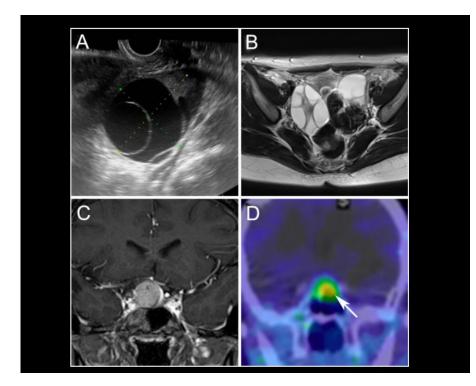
Pituitary and ovarian lesions seen on preoperative imaging. A: transvaginal ultrasound revealed a big cystic ovary with septation. B: Bilateral multi-cystic ovaries were visible on the axial T2-weighted pelvic MRI. C: A mass lesion with suprasellar extension was discovered by preoperative pituitary MRI (coronal postcontraste T1-weighted picture). D: The
